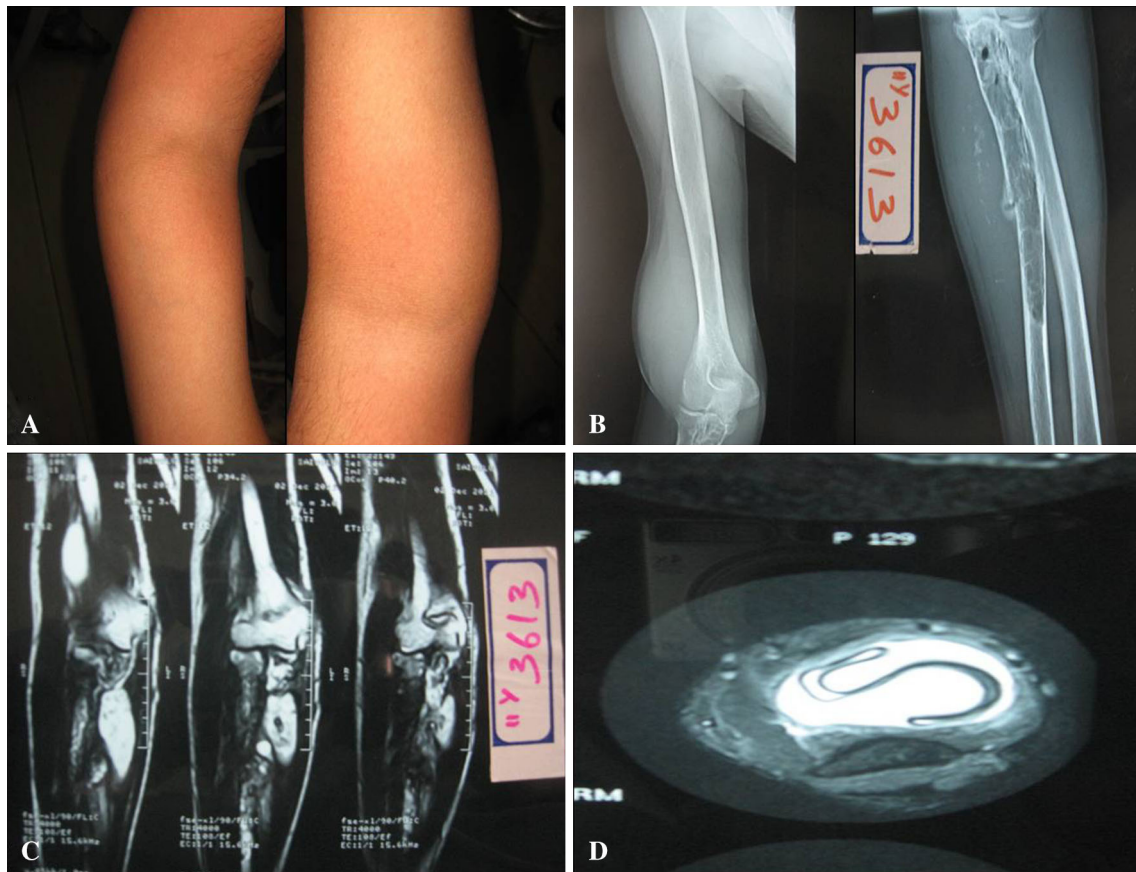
a Swelling in right arm and forearm. b Radiograph showing lytic lesion in ulna with ground glass matrix and endosteal scalloping in the distal end of humerus. c Coronal T2 weighted MRI of right upper arm shows a lesion with hyperintense signal lateral to distal
